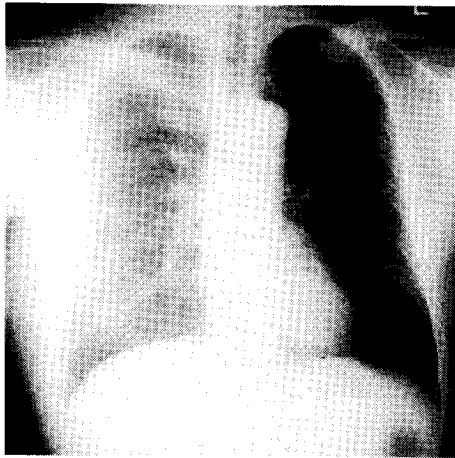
Chest radiograph showed increased radio-opacity of the right lung field due to soft tissue tumor and no evidence of tuberculosis.
